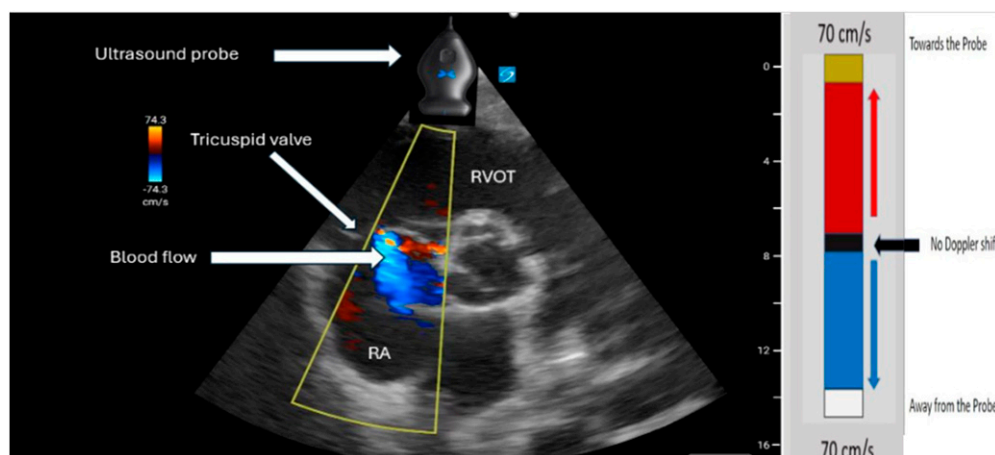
E-learning module 2 parasternal short axis base tricuspid valve view and color Doppler scale. RA = right atrium; RVOT = right ventricular outflow tract.
